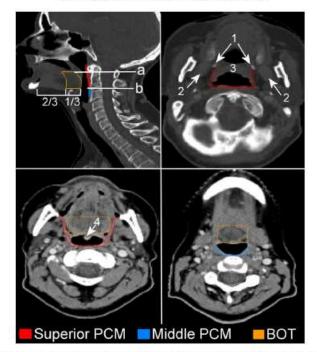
Superior PCM, middle PCM and base of tongue (BOT) in signifial and coronal CT-sikes: The upper two CT-sikes are in bone-setting. Two cranial borders are shown: (a) lower edge of anterior tubercle of atlas (cranial border of BOT) and (b) upper edge of C3 (cranial border of middle PCM). The following reference anatomical structures are shown: (1) hamalus of pterygoid plates, (2) medial pterygoid muscles, (3) soft palate, and (4) uvula.
